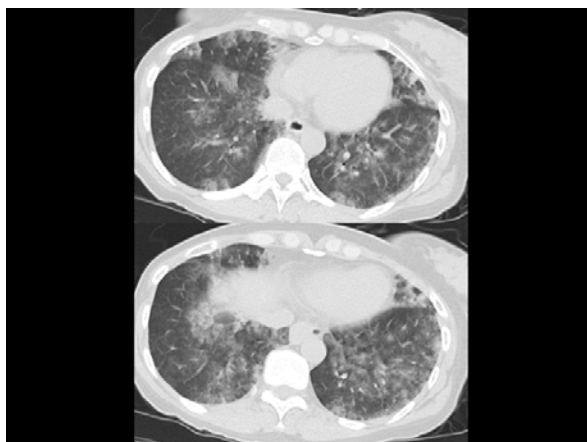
Chest computed tomography (CT) on arrival. CT showed diffuse infiltrative lesions in the bilateral lung fields. No gas was observed in the vessels or heart
